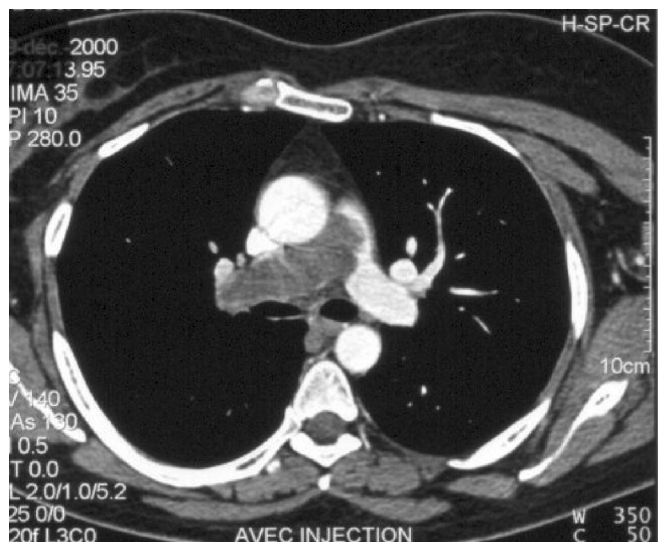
Woman, 52-year old (case 5). Helical CT with contrast: unilateral of massive perfusion defect in right pulmonary artery seems pulmonary embolism.
